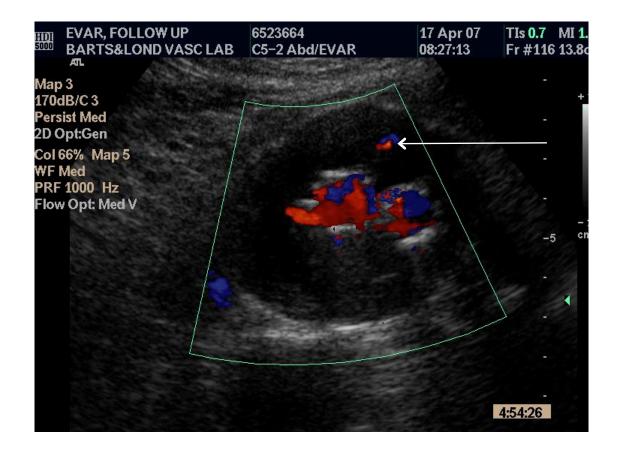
Typical appearance of post EVAR Doppler. Arrow pointing to endoleak
